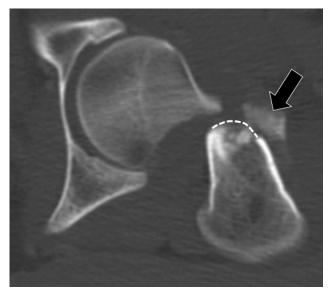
Axial CT demonstrates inferior comminution (black arrow) and inferior extent of fracture along anteromedial femoral neck with calcar deficiency (white dotted line).⁵
